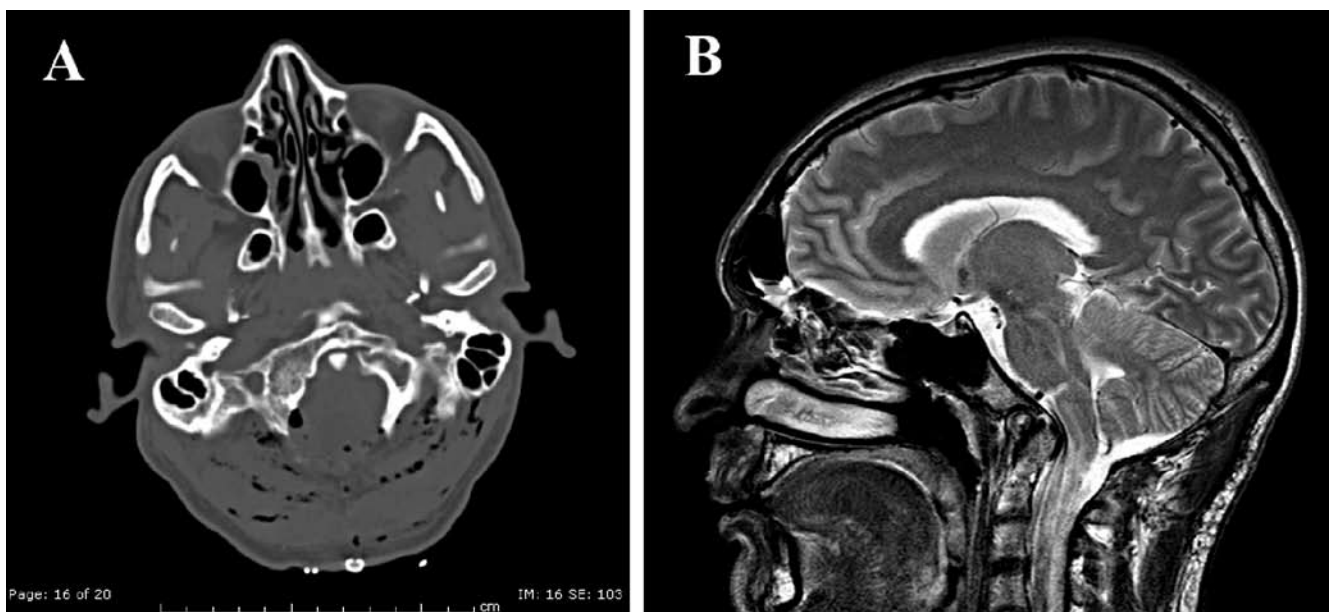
A) Axial CT scan showing the relationship between C1, C2 and the vertebral canal. The odontoid process oversteps the asymmetric atlas, and both of them are partially fused with the cranial base. B) MRI T2-weighted sagittal scan demonstrating the posterior dislocation of the dens, which compresses the brainstem at the cervicomedullary junction.
